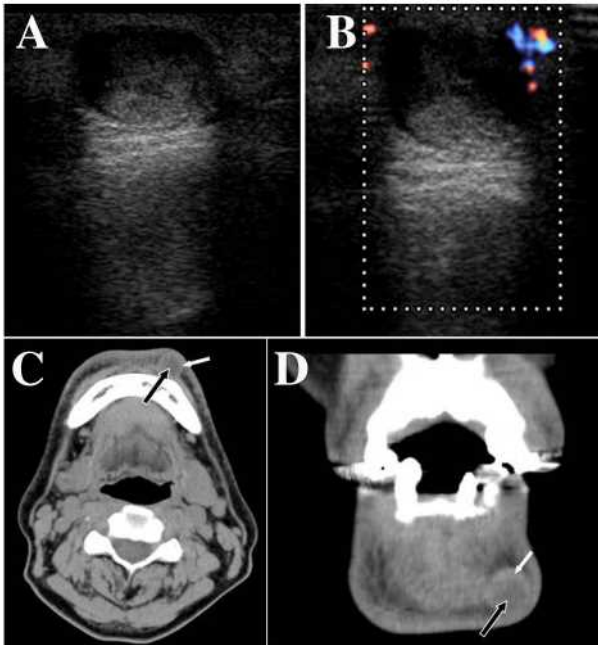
Ultrasound imaging.
